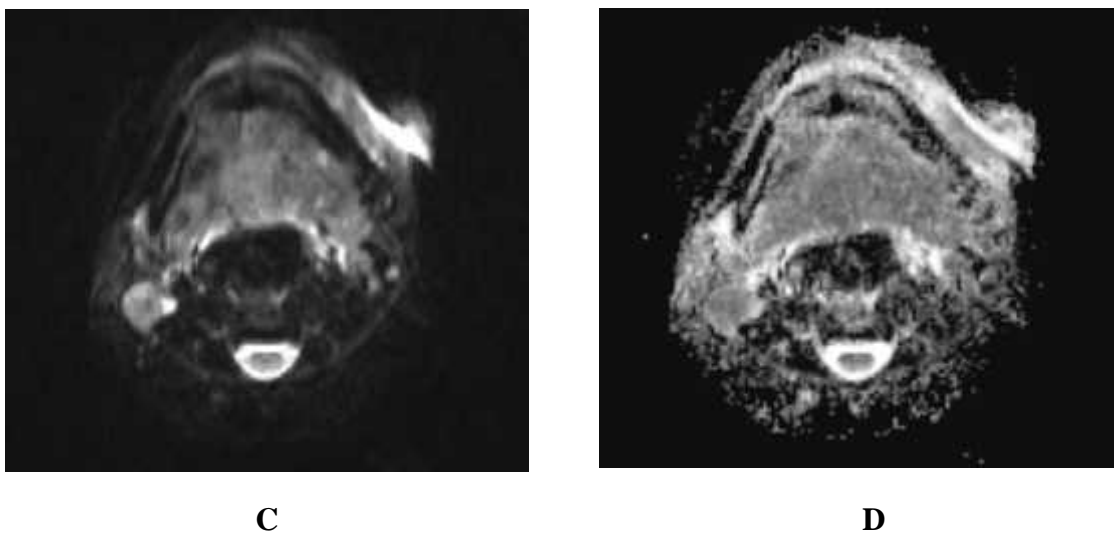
DWI at b 800- shows restriction Figure 9-D: ADC shows ofright Level II enlarged nodecorresponding low signals.
